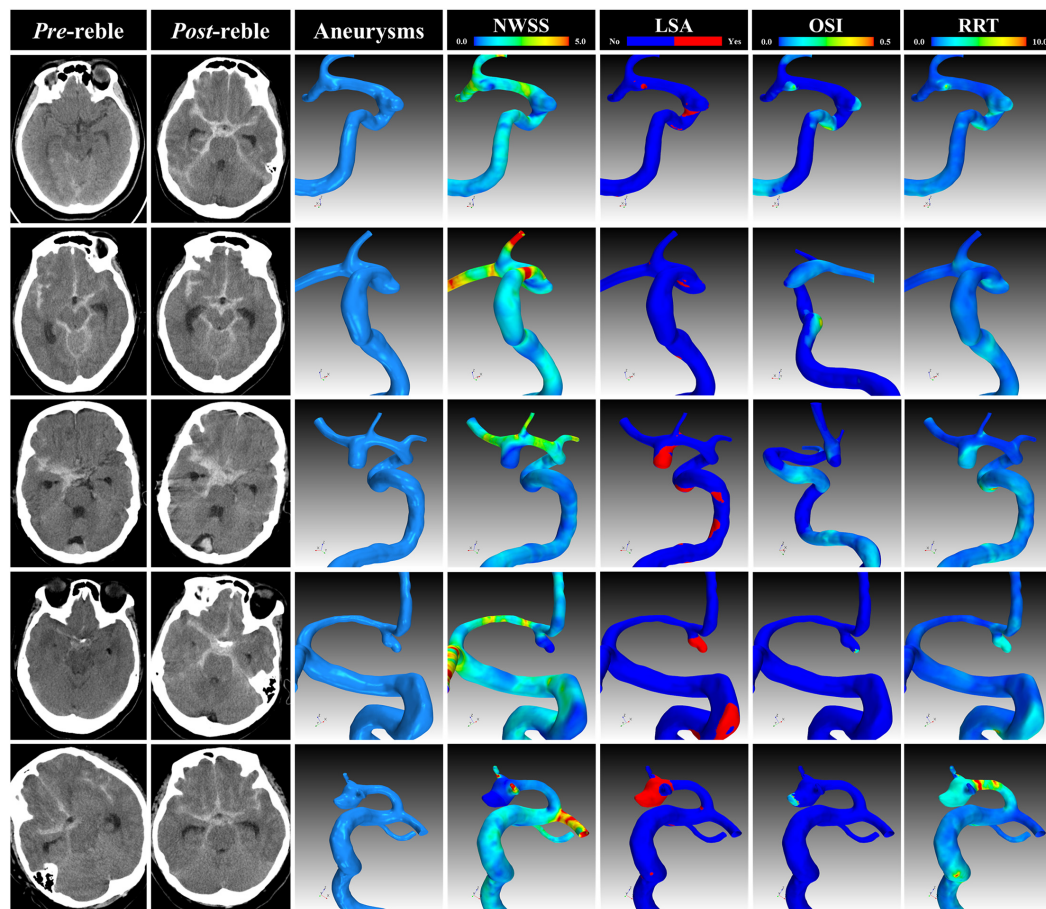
Representative cases. The CT, angiogram and hemodynamic analysis of several representative cases. CT, computational tomography; NWSS, normalized wall shear stress; LSA, low shear area; OSI, oscillatory shear index; RRT, relative resident time.
